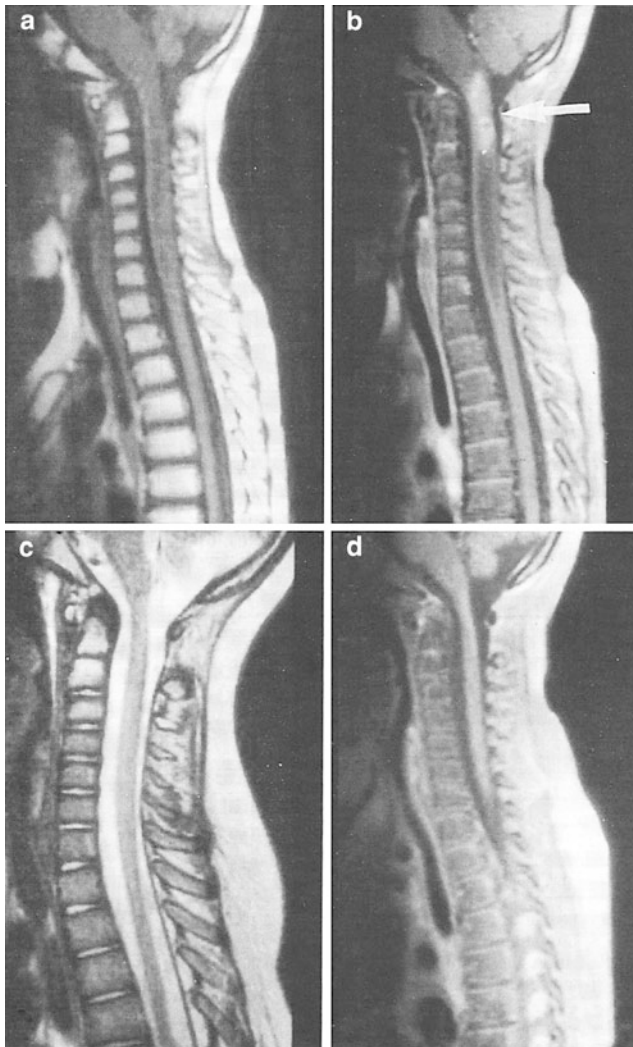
Postradiation changes in the spinal cord: chemoradiation myelitis in 8-year-old girl with history of chemotherapy and radiation for acute lymphocytic leukemia (ALL). One year after the therapy, she developed limb weakness and urinary retention. a Sagittal T1-weighted magnetic resonance (MR) image reveals hyperintense marrow and edematous cervical cord. The bone marrow shows signs of radiation changes with increased signal intensity in C1 and C2. b Sagittal T1-weighted postgadolinium MR image with fat saturation demonstrates an enhancing mass in the upper cervical cord (*arrow*). Because there was no evidence of ALL relapse, this was presumed to represent radiation myelitis. c Sagittal fast spin echo T2-weighted image 1 year later demonstrated an essentially normal cord. d Sagittal T1-weighted postgadolinium MR image with fat saturation shows that the enhancing lesion has resolved (with permission from Braggs et al. 2002)
